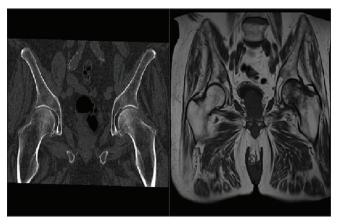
Computed tomography was reported as no fracture. Subsequent magnetic resonance imaging (T1 weighted coronal sequence) in the same patient shows a left subcapital fracture.
